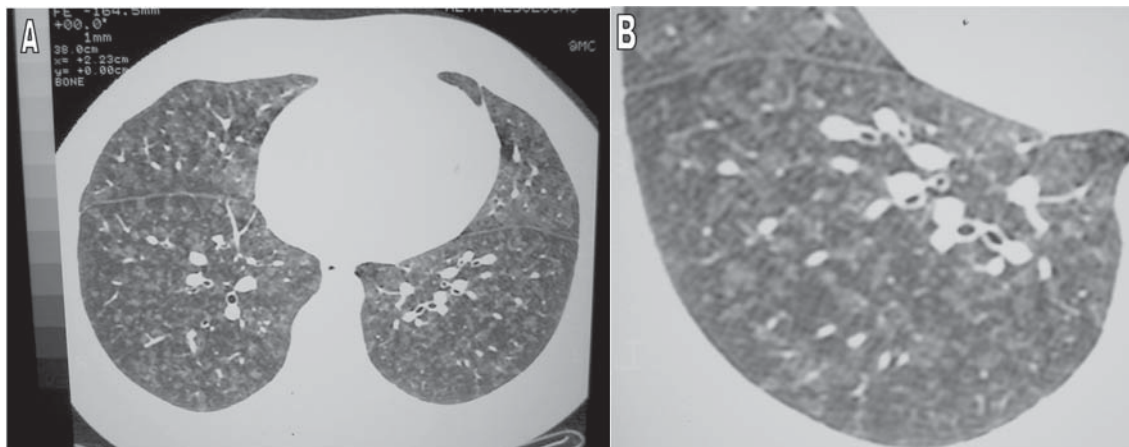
A and B) High-resolution computed tomography scan showing small, ill-defined bilateral nodular opacities and a diffuse ground-glass pattern
